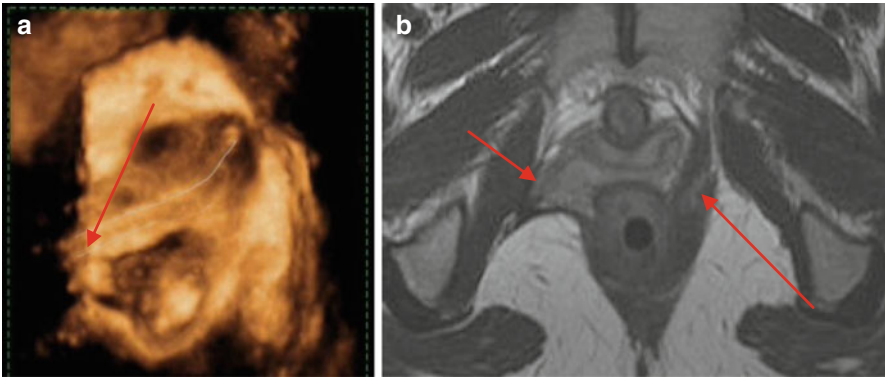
IFIP of right pubococcygeal muscle avulsion after childbirth traumatic vaginal delivery: compared to 3-D rendering TPUS (a), axial MR imaging (b) offer better evidence of the paravaginal defect (*short arrow*) and the focal discontinuity with increased signal intensity from fibrofatty degeneration (*long arrow*) of the left hypertrophic pubococcygeal muscle
